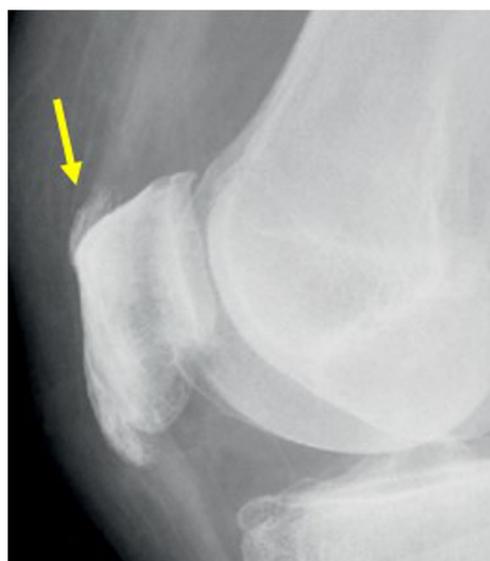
Lateral plain radiograph showing enthesophyte at the distal end of the quadriceps tendon (yellow arrow)
